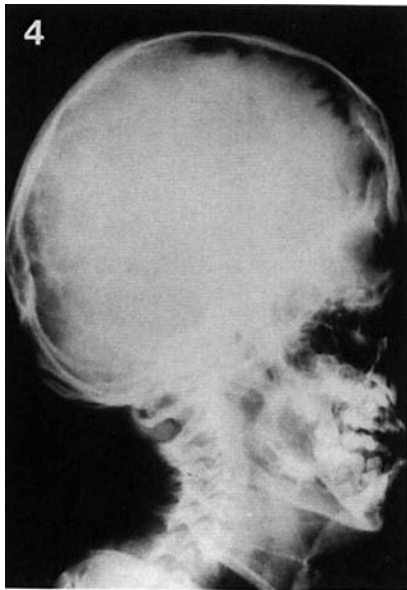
Radiograph of girl with CFNS shown in Figure 3. Note coronal synostosis.
